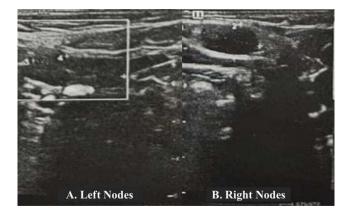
Ultrasonography of the neck revealed that the patient had bilateral cervical lymphadenopathy. The right level 5 nodes measured 2.5x1.0 cm, and the left level 4 node measured 1.9x0.8 cm.
